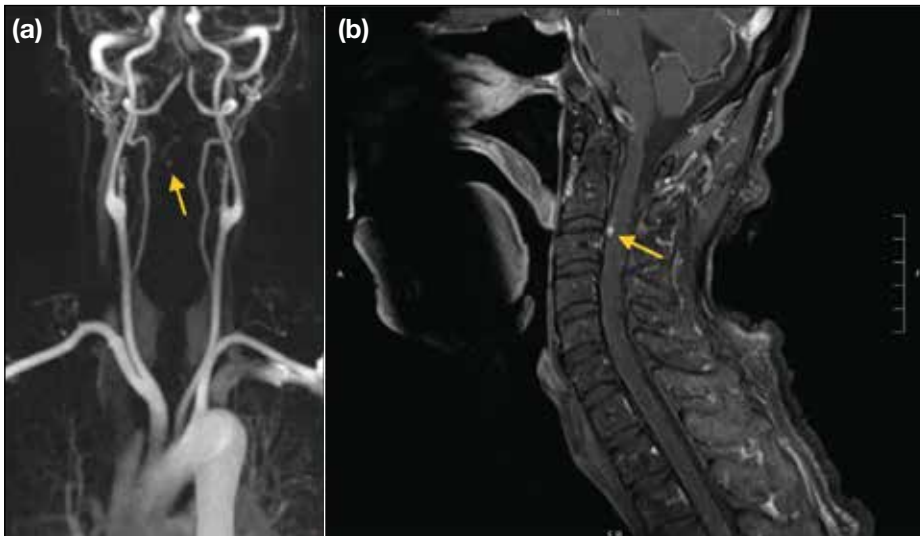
(a) Time-resolved magnetic resonance imaging angiography and (b) post-gadolinium T1-weighted magnetic resonance imaging with fat saturation of the cervical spine. The radiculomedullary aneurysm (arrows) is demonstrated as an enhancing lesion in the spinal canal.
